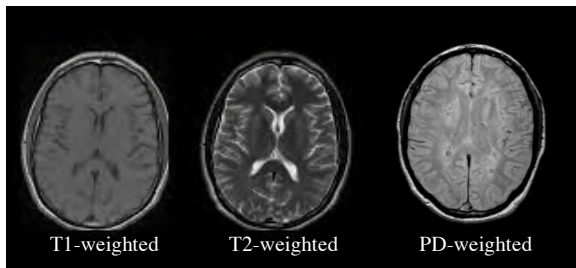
Representative example of an axial slice through the human brain from a T1-weighted, T2-weighted and proton density (PD)-weighted MR image.
